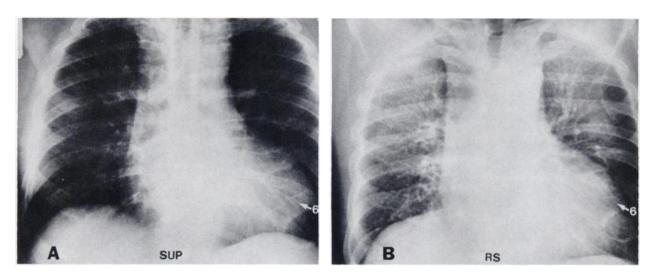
Supine (A) and right lateral decubitus (B) anteroposterior chest radiographs of same patient. With patient on his right side, left hemidiaphragm is moved caudad, with more separation between diaphragm and heart. Left sixth rib (arrow) is identified for reference. RS = patient on his right side; SUP = patient supine.
